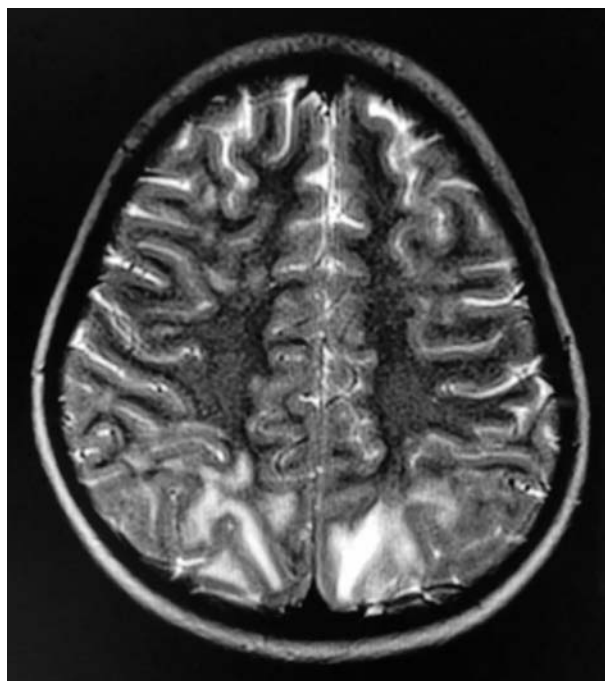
MRI brain T2 sequence showing hyperintense areas in subcortical white matter of bilateral occipital lobes.
